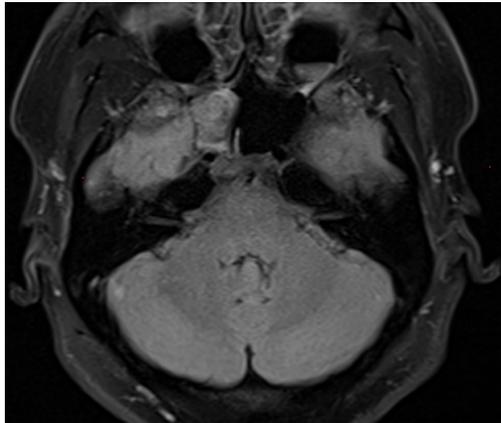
Axial FLAIR shows the herniated brain parenchyma at the right recess of the sphenoid sinus
